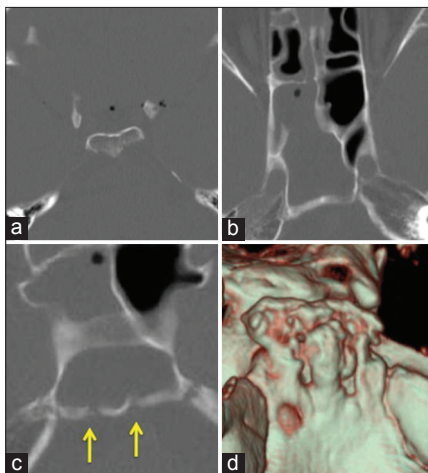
A CT scan of the axial images reveals (a) multiple intracranial air bubbles and pneumatization of the dorsum sellae, (b) fluid accumulation in the sphenoid sinus, and (c) bony defects at the clivus (arrows). (d) Reconstructed three-dimensional CT image clearly demonstrates multiple bony erosive defects at the clivus
